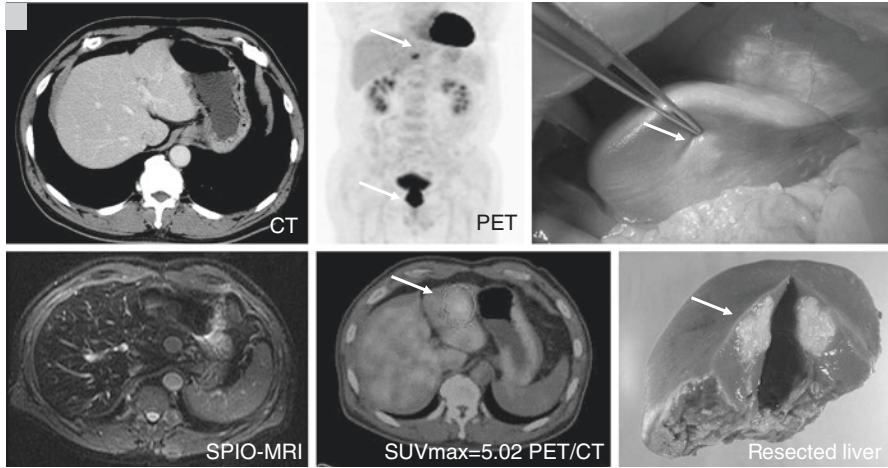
The patient was a 55-year-old man with rectal cancer and liver metastasis. The liver metastasis was undetectable on CT and MRI, but was revealed from a PET/CT
